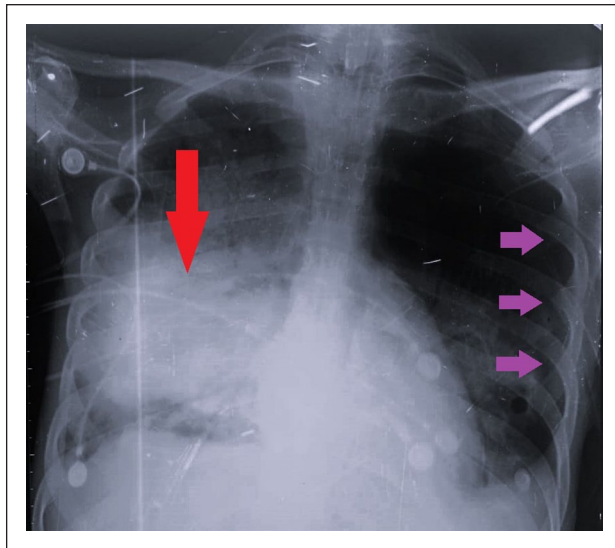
An anterior/posterior view of the chest X-ray showing right-sided consolidation (red arrow) and left-sided pneumothorax (purple arrows).
